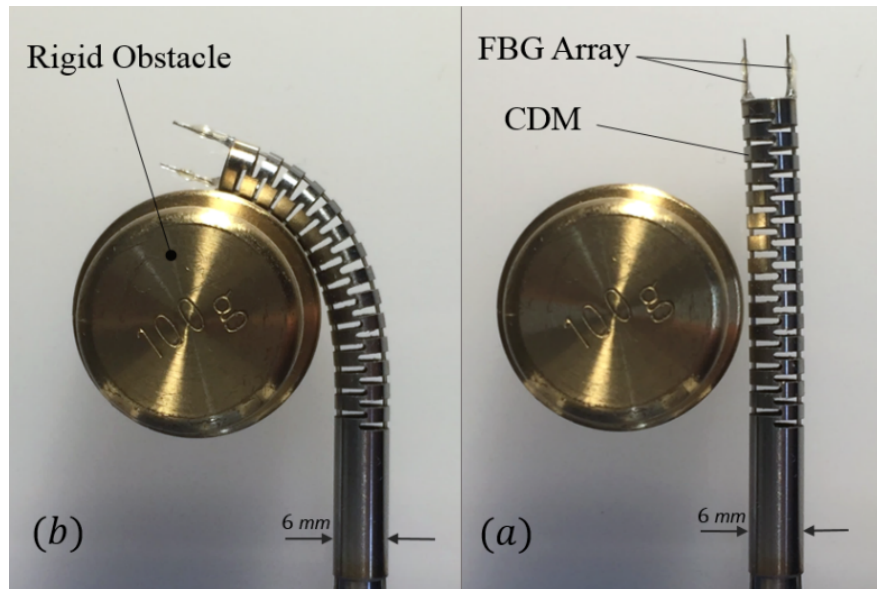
The CM in interaction with hard obstacle: (a) straight configuration (b) bending configuration (c) x-ray image of the CM inserted into the screw holes of the acetabular component
